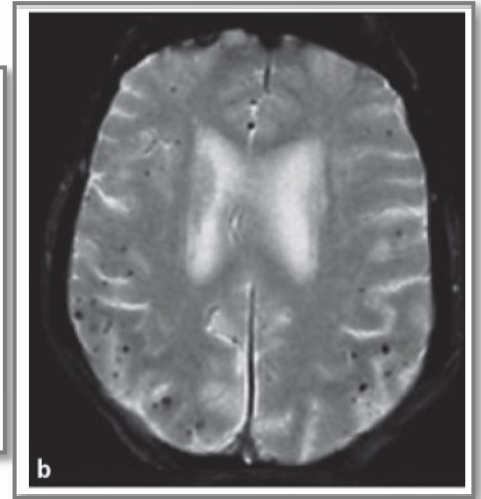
Cerebrovascular pathology on axial fluid attenuated inversion recovery (FLAIR) MRI scans. Confluent white matter changes (Fazekas scale 3).
